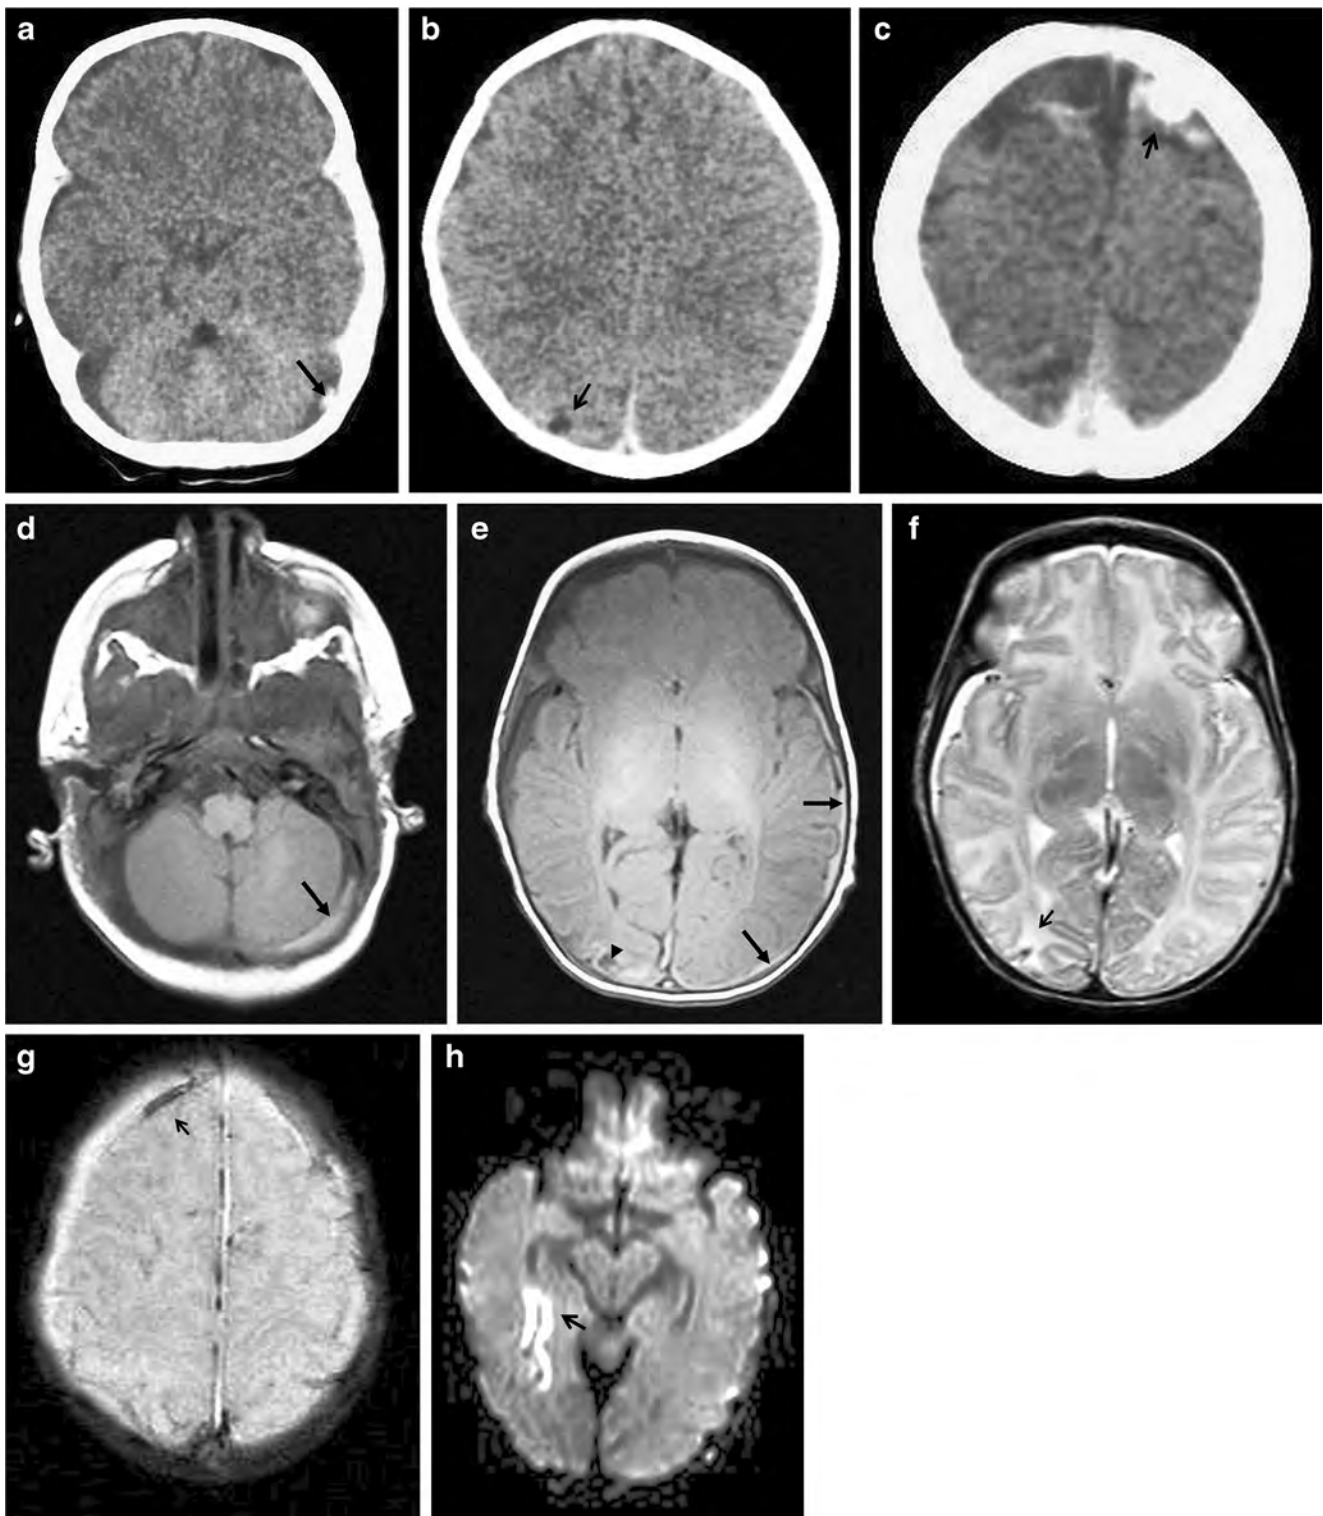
Additional value of DWI in a 7-week-old boy with abusive head trauma. The patient had an antecedent of previous gastric perforation and was admitted with seizures and obtundation. a–c Axial CT images disclose (a) posterior fossa subdural collection suggesting several ages, with hypodense fluid as well as a hyperdense area (*arrow*), together with (b) a right parietal chronic parenchymal lesion (*arrow*), and (c) areas of hyperdensity near the vertex (*arrow*), representing recent subdural
